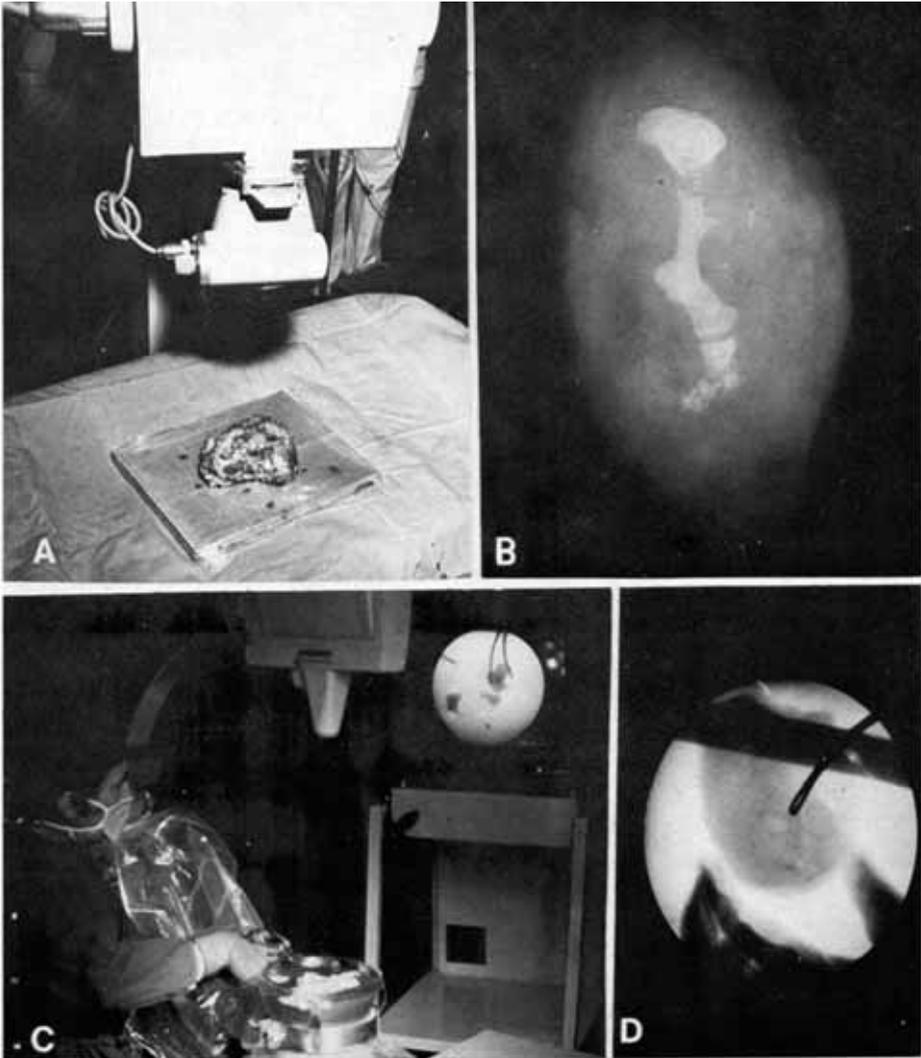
(A) Kidney is brought to radiology department; (B) contact radiography: stone and calcifications are detailed; (C) image amplifier helps to locate and extract calculus with minimum trauma (dish containing kidney is radiotransparent); (D) television image: Randall's forceps is easily directed toward bottom of calyx to remove small stone.
